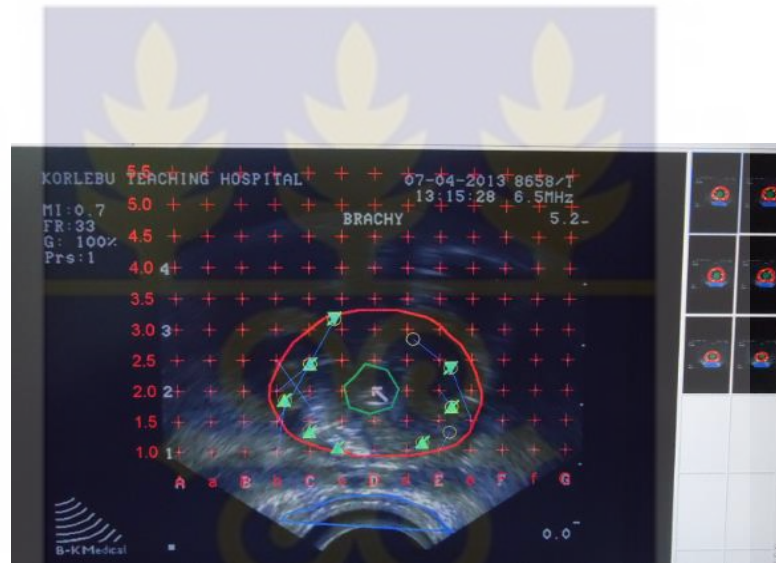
The Ultrasound image, indicates the number of slices which was summed up to get the prostate volume.
